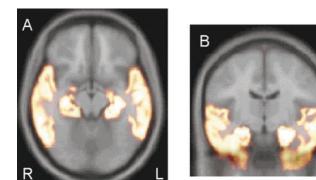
After the PET was spatially normalized into average MRI template, the counts from the PET were multiplied by the probability of each VOI of SPAM. Then counts were normalized with average gray matter counts. These figures are examples of the left hippocampus; probability-weighted average PET count of the left hippocampus was 103. PET, positron emission tomography; MRI, magnetic resonance imaging; SPAM, statistical probabilistic anatomical mapping; VOI, volume of interest.
